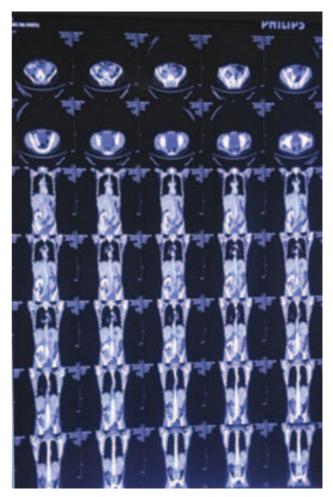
CT Aortography showing occlusion in descending aorta.
